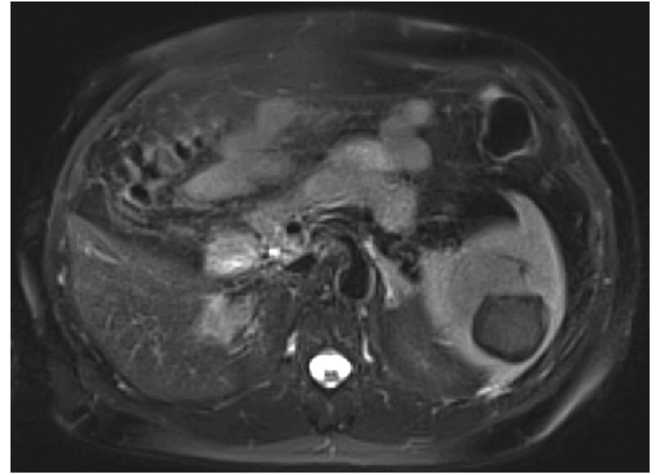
MRI slice of the smaller cystic lesion with low intensity signal in both T1 and T2 sequences.
